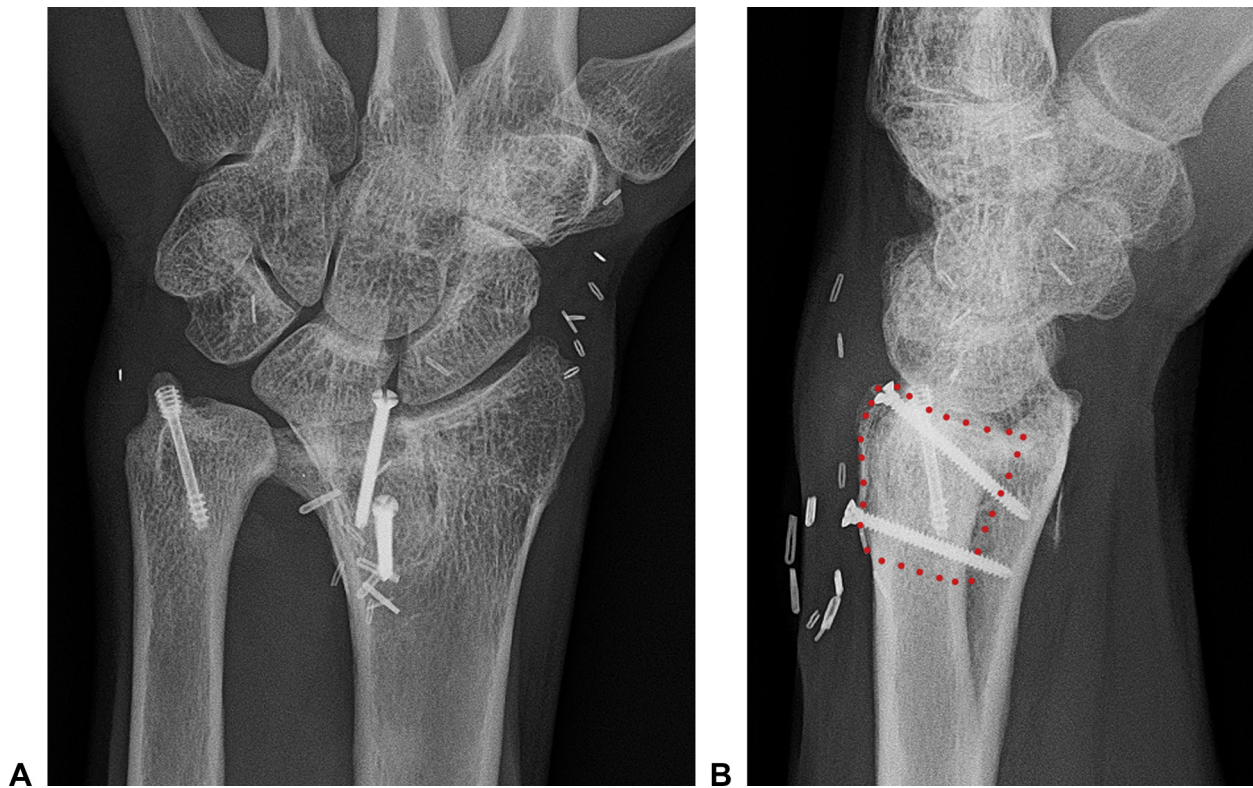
A, B Posteroanterior and lateral x-rays at 2 years, in the same patient (patient 6) as Figures 2 and 5.
